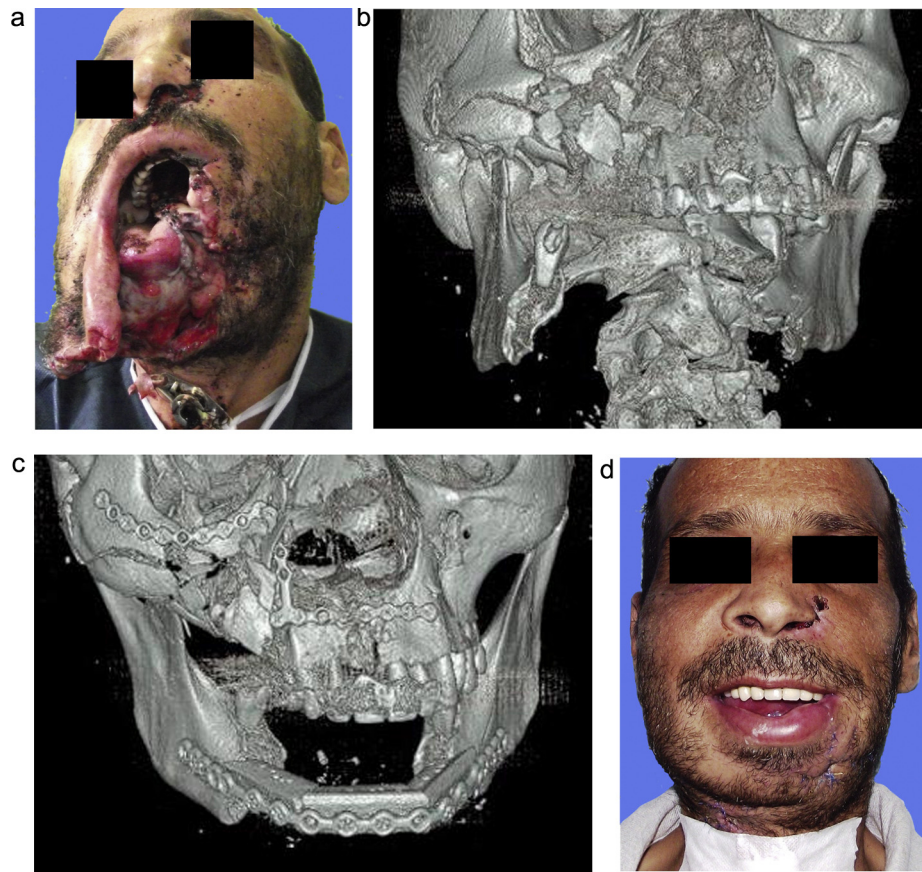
A wide segmental bone defect at mandible was seen in association with partial soft tissue defect (a). Three-dimensional CT was used to determine size of defect and to plan reconstruction (b). Reconstruction was performed by using non-vascular fibula bone graft (c) and a satisfactory result was achieved in this case (d).
